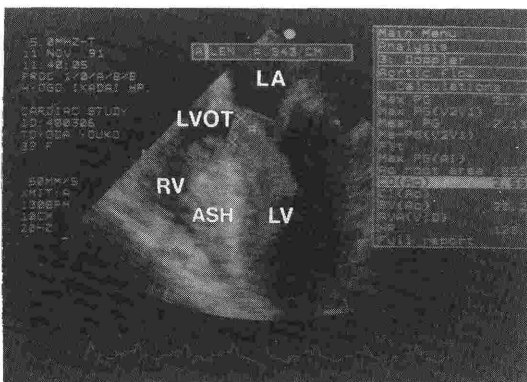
Transesophageal echo four-chamber imaging shows the following : during manipulation of pheochromocytoma, the peak left ventricular outflow tract pressure gradient (PG) was 21 mmHg.
